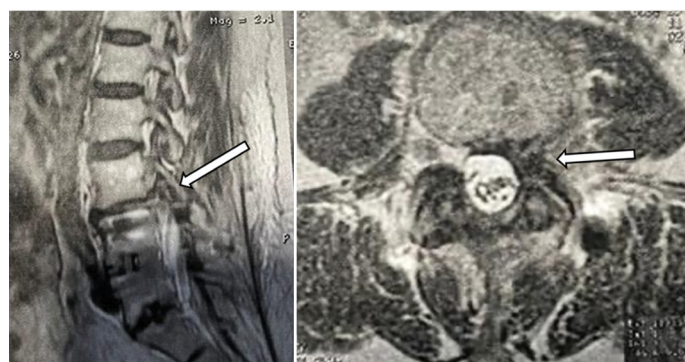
Sagittal and axial cut of the preoperative MRI, showing extruded disc herniation and left L3-L4 foraminal stenosis.
